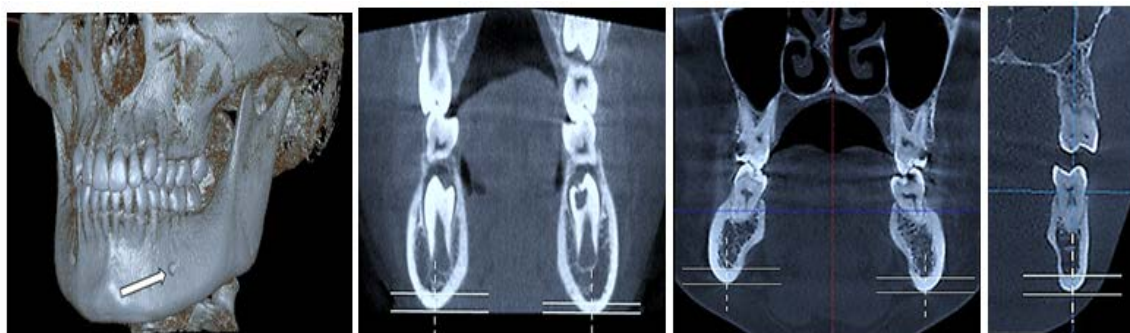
Cone-beam computed tomography in the region of premolars, angle of mandible (a). Determination of the thickness of the cortical layer on the frontal sections (b, c, d)
